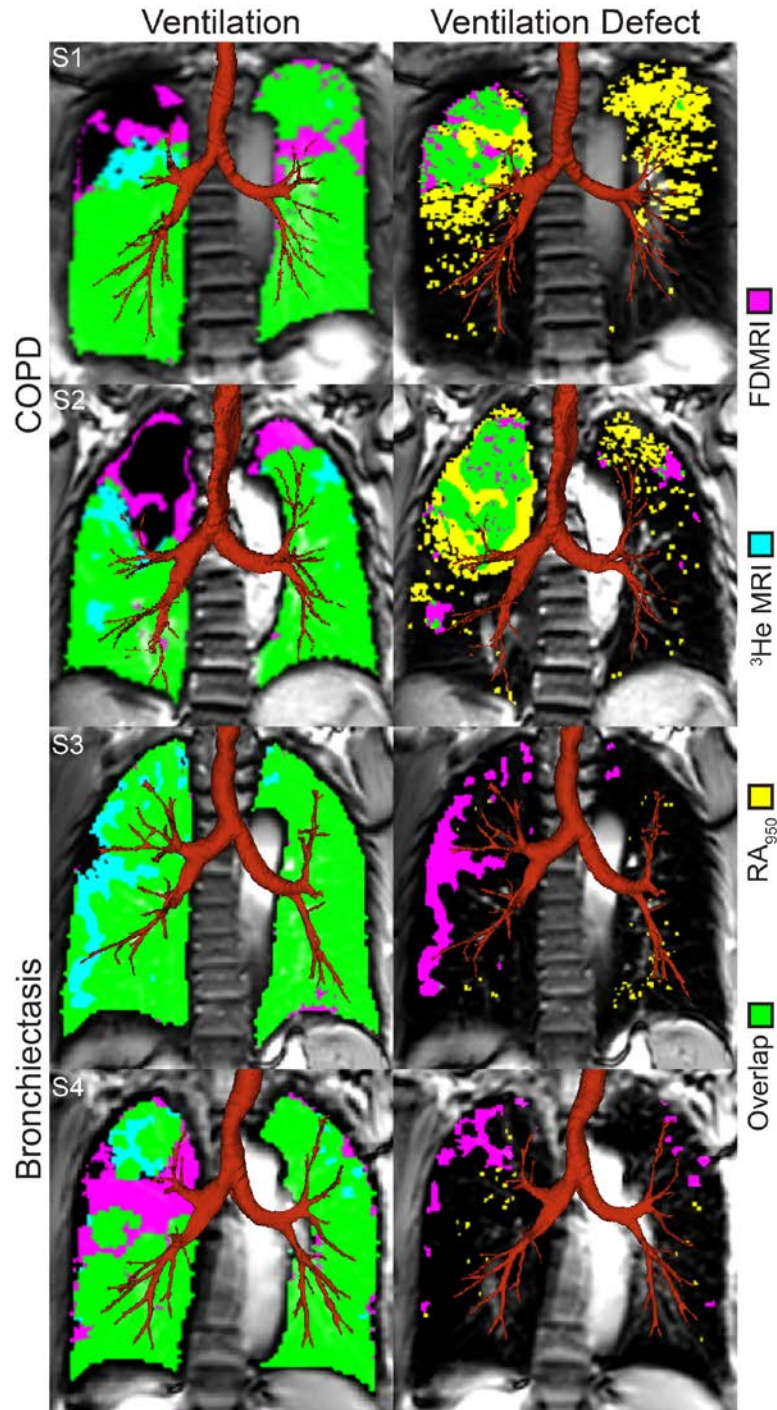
Spatial relationship of FDMRI with ^3He MRI ventilation and emphysema for representative subjects with COPD and Bronchiectasis
